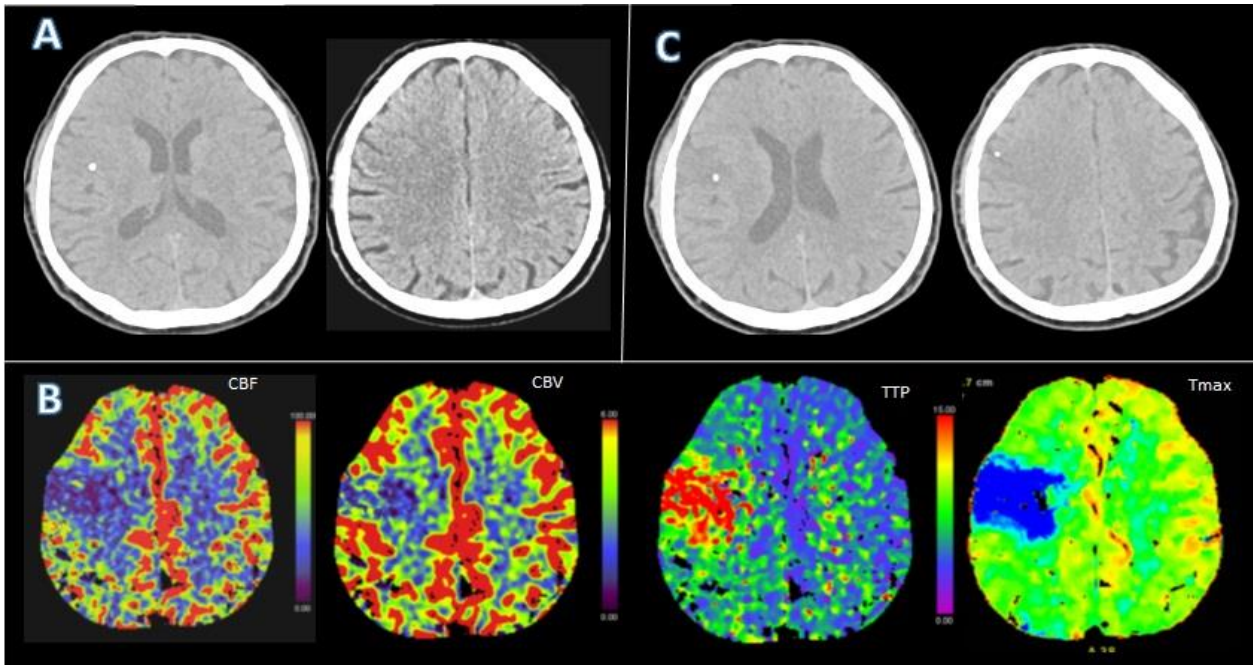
A: Calcified embolic material (arrow) on unenhanced CT B: Perfusion CT reveals a penumbral pattern [CBV<CBF<MMT]. C: After IV tPA, the cross-sectional area of calcified emboli appears to decrease. Additionally, a second, smaller piece was visualized distally and is consistent with embolic fragmentation.
